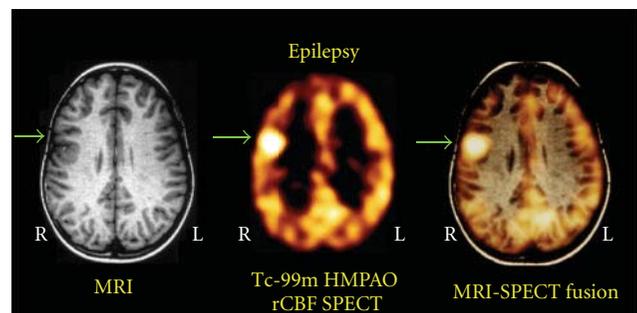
Tc-99m HMPAO ictal brain SPECT scan section (middle) showing a focal area of hyperperfusion in the right premotor area. The right to left asymmetry in blood flow for this region was 1.32, and the intensity of uptake in the right frontal lobe measured 1.13 (cortical to cerebellar ratio) with a range of normals = mean \pm 1SD of 0.90 ± 0.07 . The ictal brain SPECT scan was subsequently coregistered with the MRI scan (left). The resulting fusion image (right) shows the anatomic location of the epileptogenic focus, which was surgically excised, and the patient was rendered seizure-free.
